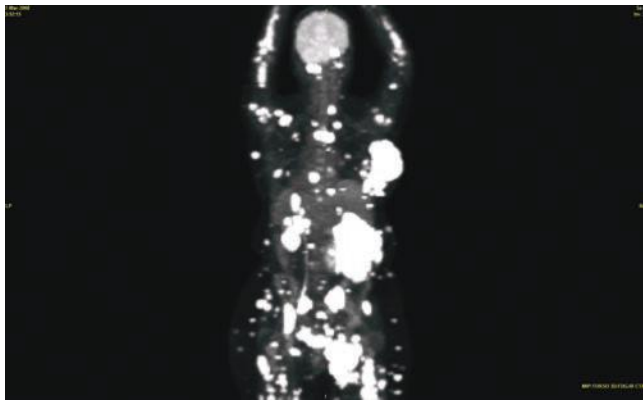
PET-CT scan showing multiple soft tissue plasmacytomas in a patient with negative marrow biopsy.
